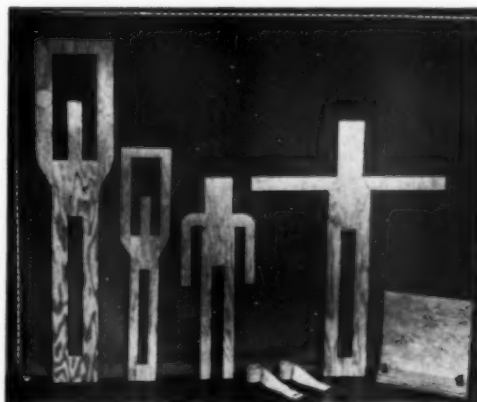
"Boards" for immobilizing children during radiography and "vise" for holding "boards." The two "boards" on the left are used when the arms are to be bound beside the head. The larger one is for children from a few months to several years of age. The smaller "board" is for infants. The third "board" is used for infants and children when the arms are to be held at the sides. The fourth "board" is for use when the arms are to be held laterally at right angles to the body. In the lower right corner is the "vise" for holding the "boards" vertical to the table top. The jaws are resting horizontally on the table top and the base is vertical. The two elastic bandages are shown between the third and fourth boards. The scales at top and side of the picture are in inches. The vise is 12 inches wide.
